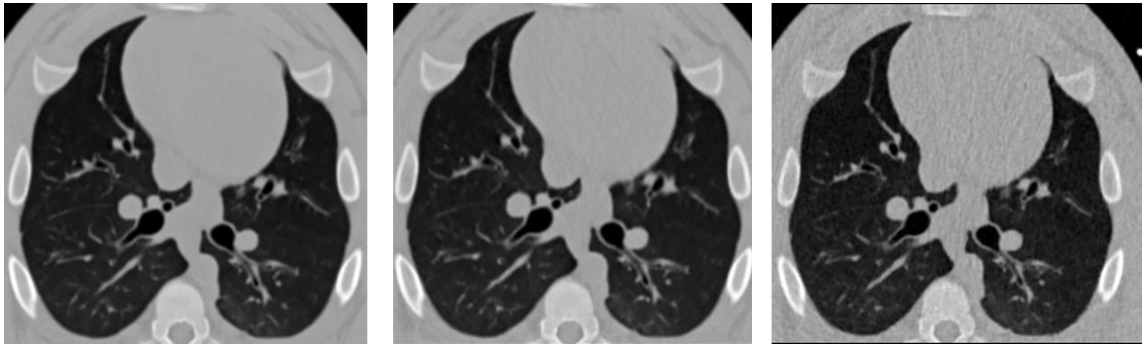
Axial slices from chest CT data of subject 40016. Three different CT protocols were used (from L-R) high (14.98 mGy), medium (6.00 mGy), and low (0.74 mGy) radiation doses. Increased noise is evident in the heart and soft tissue of the thorax in CT data acquired at lower radiation dose levels.
